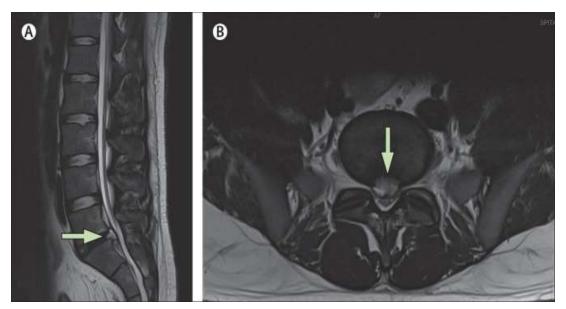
(A) Sagittal view of lumbar MRI, with arrow pointing to L5-S1 intervertebral disc. (B) Axial view showing L5-S1 herniated disc. Nucleus pushing through annulus, beyond intervertebral disc space.
